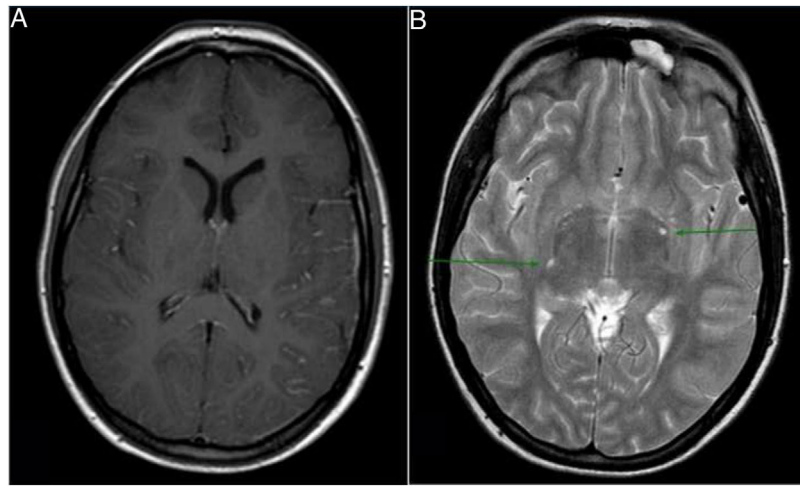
(A) Axial T1-weighted sequence with contrast administration showing leptomeningeal enhancement. (B) Axial T2-weighted sequence showing dilated Virchow-Robin spaces (arrows).
